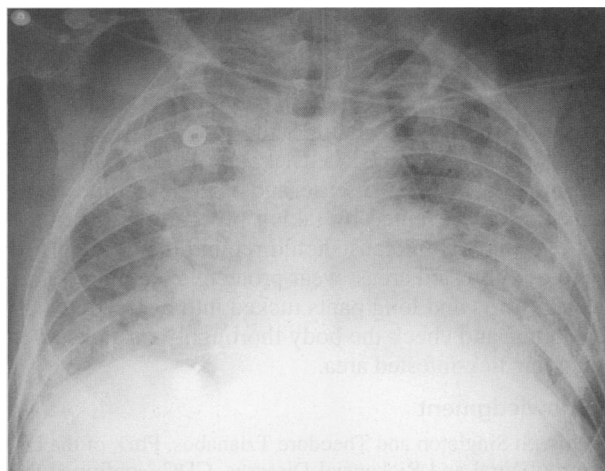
A chest radiograph shows diffuse bilateral infiltrates consistent with the adult respiratory distress syndrome.
